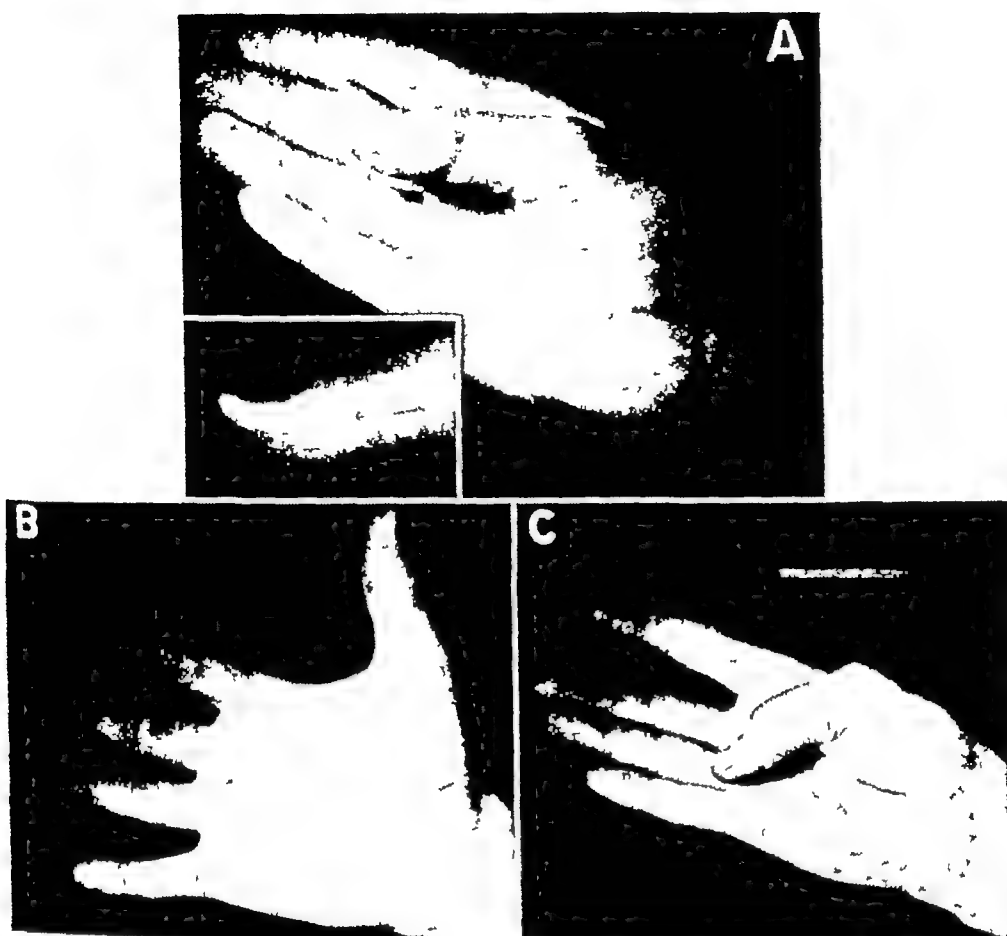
Saw cut of thumb which severed digital nerve and flexor tendon treated primarily by simple wound closure and splinting. One month later tendon and nerve repair was done, with the defect in phalanx covered with flap of tendon sheath and fat. *A*, original wound healing, and x-ray showing bone defect. *B* and *C*, function five months later. Primary repair is contraindicated in this situation.
